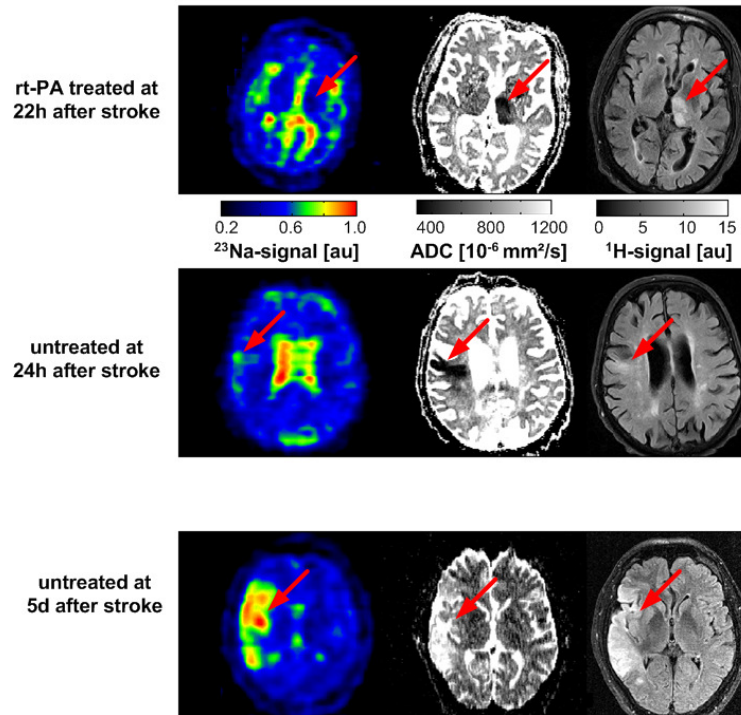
^{23}Na -MR images (1st column), ^1H ADC maps (2nd column), and ^1H T2-weighted images (3rd column) for three patients at different times after ischaemic stroke. Note the decrease in ^{23}Na signal intensity in the treated patient at 22h after stroke.
